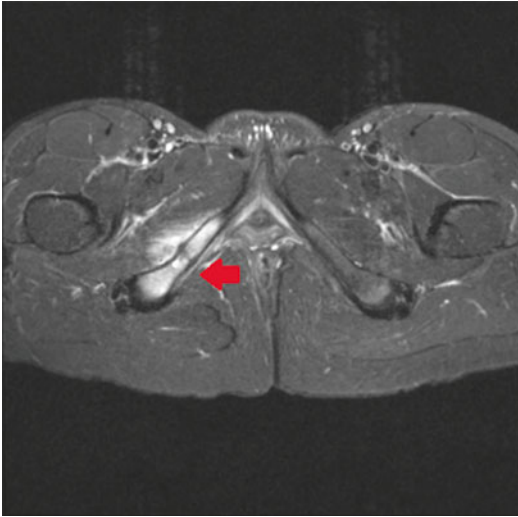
Axial cut T2 MRI of the pelvis demonstrating a Grade III (complete non-displaced) stress fracture of the right inferior pubic ramus in a 19-year-old female collegiate distance runner with worsening right anterior pelvic pain over a 4-week period and absent menses for 5 months
